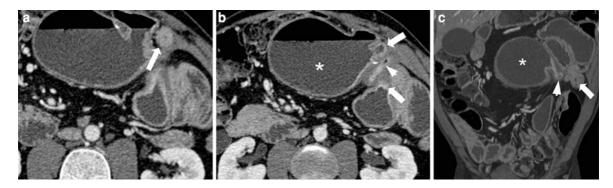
Contrast-enhanced axial (a, b) and coronal (c) CT scan showing recurrent Crohn disease some years following surgical resection. Images show mural thickenings (*arrow*) involving
